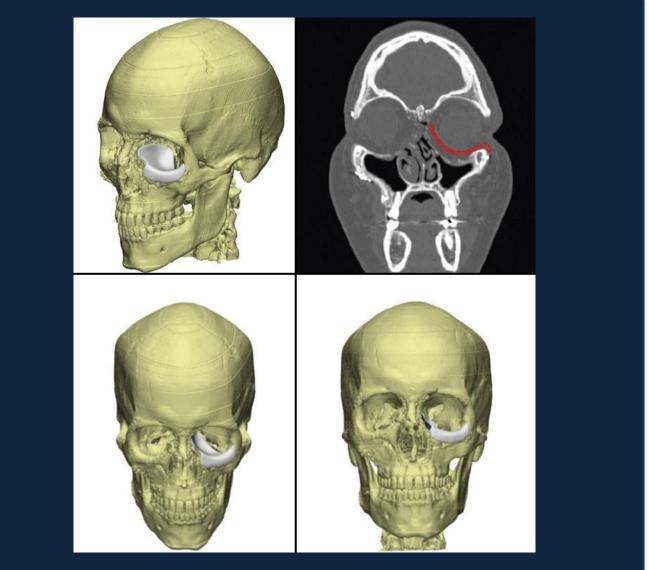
3D reconstruction of orbit from high resolution CT scan
